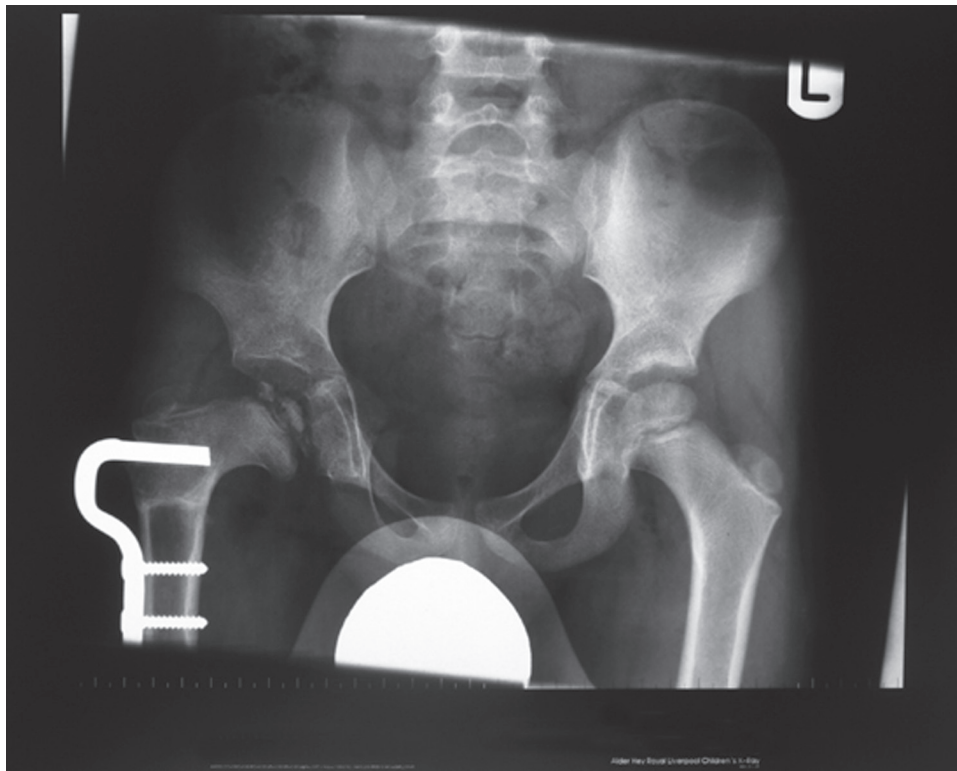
Radiograph at 1 year postreduction. This demonstrates the blade plate in-situ following a right femoral varus osteotomy. The epiphysis is well contained within the acetabulum and is late in the fragmentation stage of AVN. >50% collapse of the lateral pillar (equivalent to a Herring C hip).
